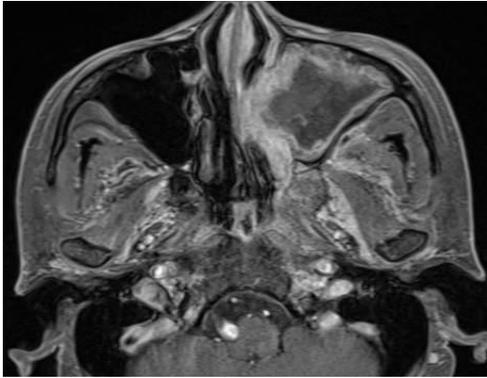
MRI-Aspergillus in left maxillary sinus with extension anterior and posterior to the retroantral space and muscles of mastication. Low signal on T1WI and T2WI weighted images
